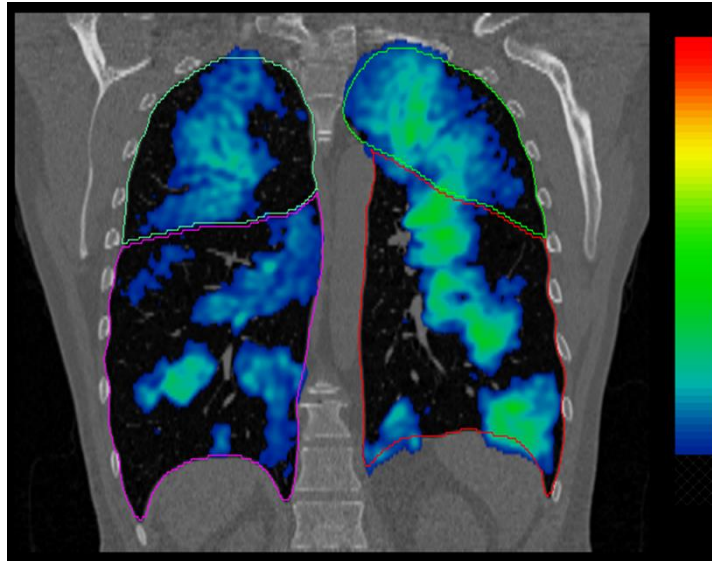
Example slice of patient 11 showing the CT lobar masks fused with ^3He MRI after registration.
